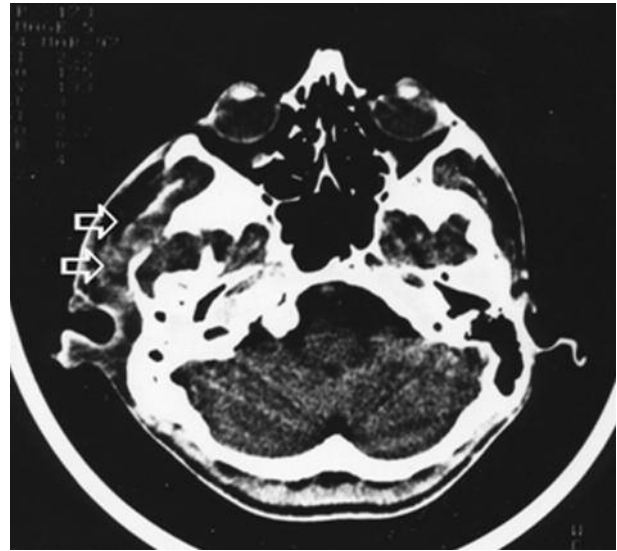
CT scan presents extension of cholesteatoma and inflammation with extracranial abscess in the region of temporal muscle (arrows)
